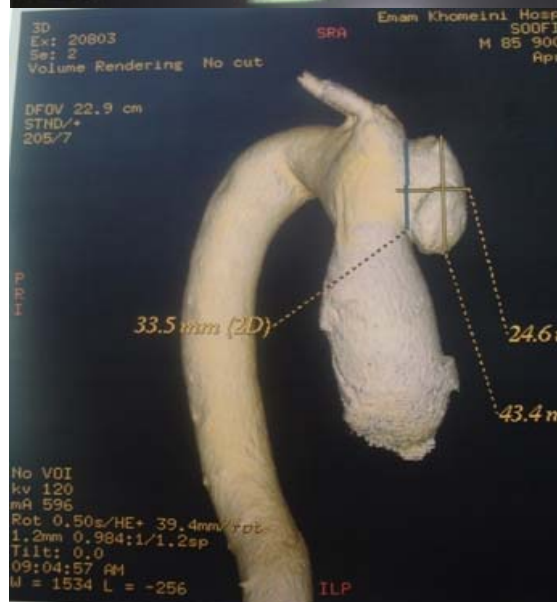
CT-angiography of aorta at presentation
